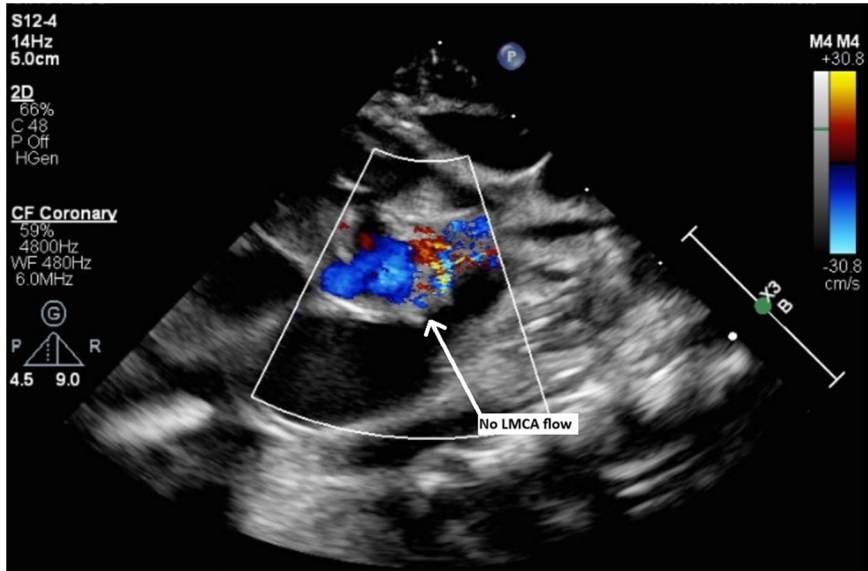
Two-dimensional transthoracic echocardiography with color-flow Doppler (reduced Nyquist limit), parasternal short-axis view, demonstrates no evidence of flow in the LMCA.
